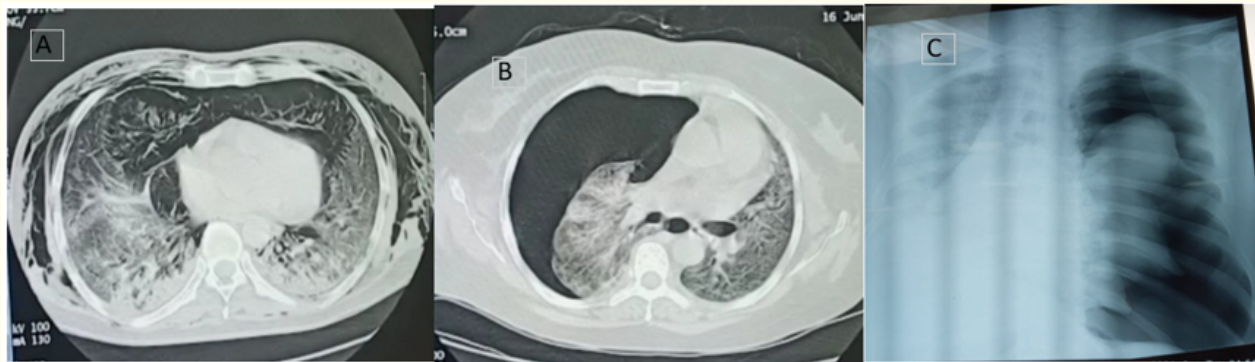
(A) Pneumomediastinum with bilateral ground glass opacities with subcutaneous emphysema at 3rd week of onset of symptoms and this patient died after 3 days of diagnosis of pneumothorax; (B): Right pneumothorax with associated precipitating bullous cystic lesions with left shift of mediastinum with gross ARDS in right lung at 5th week of symptoms onset in patients of COVID-19 NIV; (C): Chest radiograph of COVID-19 patients on NIV have left pneumothorax with passive collapse of left lung with ground glass opacities in right lung.
